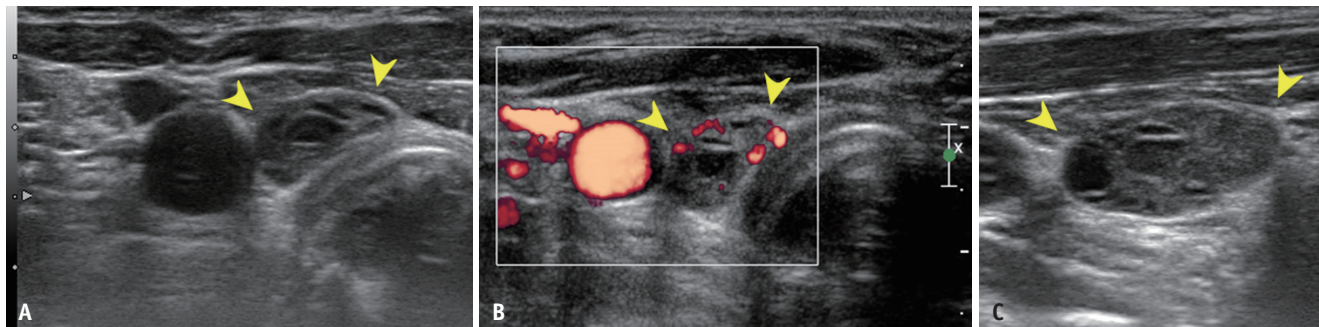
A 52-year-old female with a history of right lobectomy due to papillary thyroid cancer 12 years previous. The lesion was surgically confirmed as parathyroid adenoma. A-C. Axial gray-scale (A), axial color Doppler (B), and sagittal gray-scale (C) ultrasound views show a 1.4 cm well-defined cystic and solid hypoechoic mass (arrowheads) at the right thyroidectomy bed. The sonographic impression of the lesion was malignant (recurrent thyroid cancer). The pathologic result of the core-needle biopsy was a parathyroid lesion.
